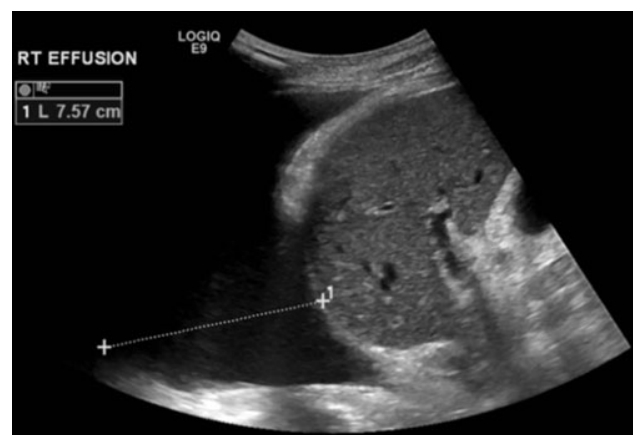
Lateral transthoracic ultrasound view showing a large right-sided pleural effusion (measurement line).
